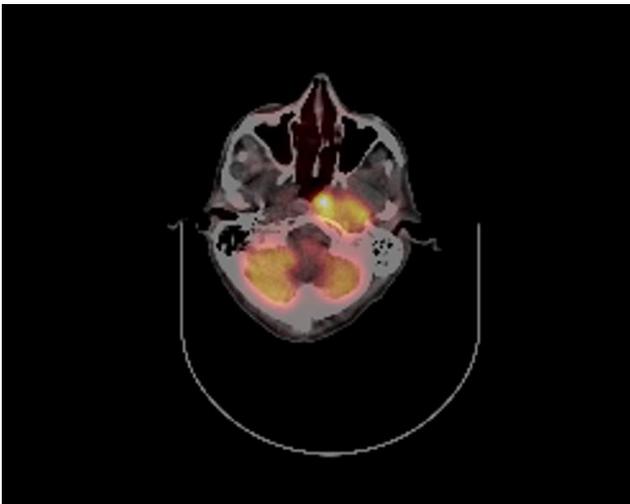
PET/CT images of the mass in the nasopharynx.
